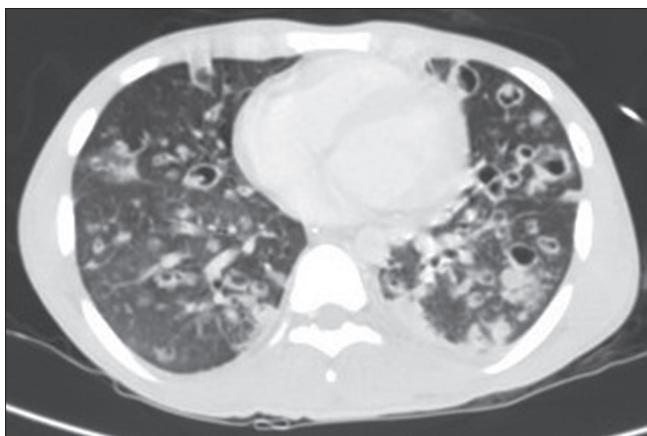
Computed tomography scan chest with contrast showing cavitary lesions
